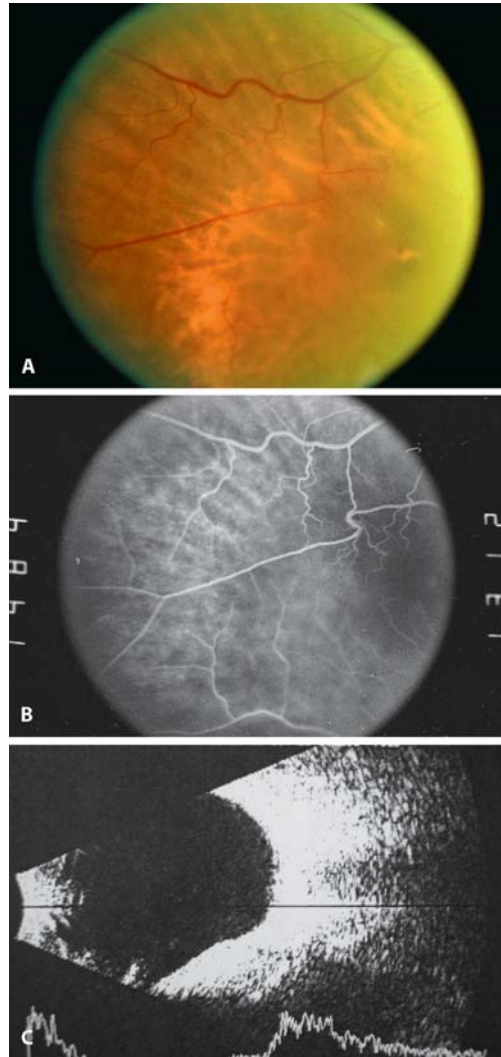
A–C. Staphyloma associated with choroidal folds in a young male patient. A Colour photo. B Fluorescein angiogram. C Ultrasound B-scan
